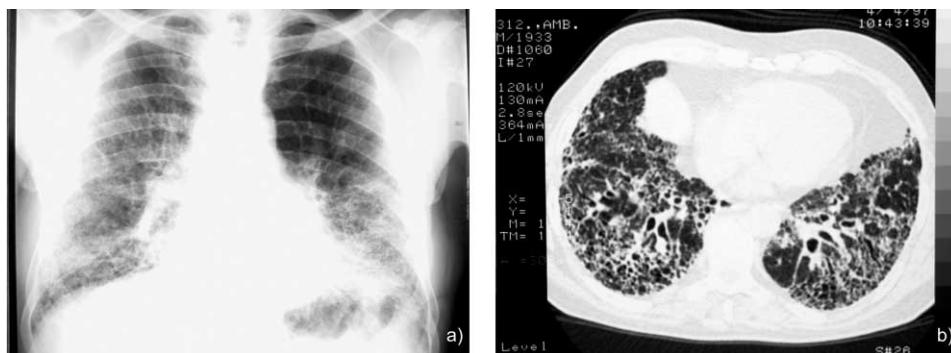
Idiopathic pulmonary fibrosis – end stage of the disease. a) ILO standard radiograph t/t 3/3; b) CT-scan peribronchovascular interstitial thickening, irregular intralobular interstitial thickening, honeycombing traction bronchiectasis
